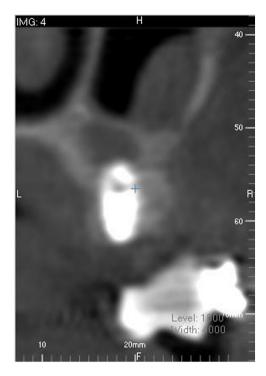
CT imaging of complete horizontal septa and implant in Case 1.
